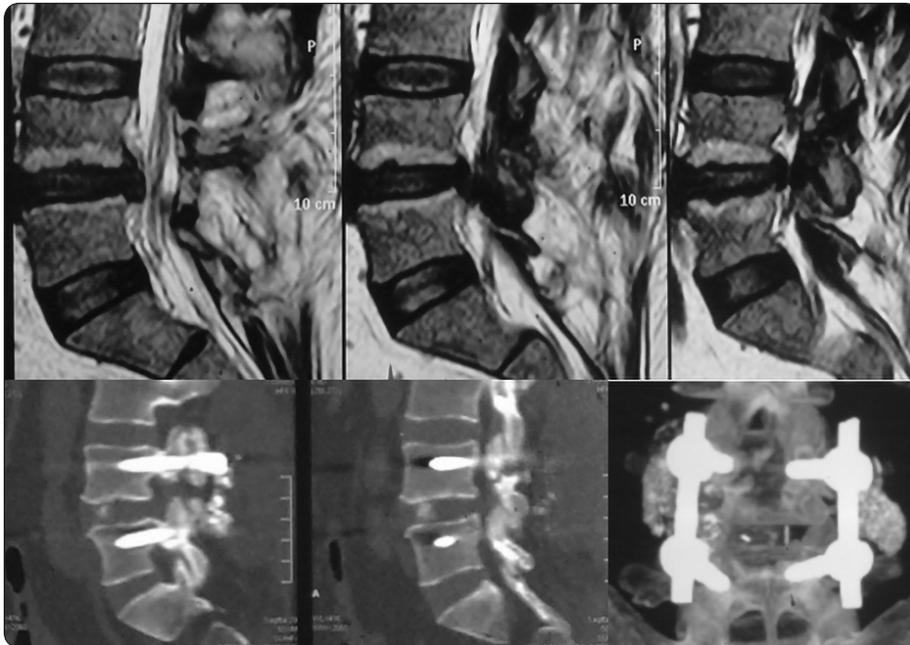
Preoperative T2-weighted sagittal MR images (upper row) and postoperative reconstructed computerized tomography images (lower row) for a patient with L4-5 disc herniation associated with type II MC. The patient underwent discectomy with both intertransverse and interbody fusion with removal of the caudally migrated disc fragment.
